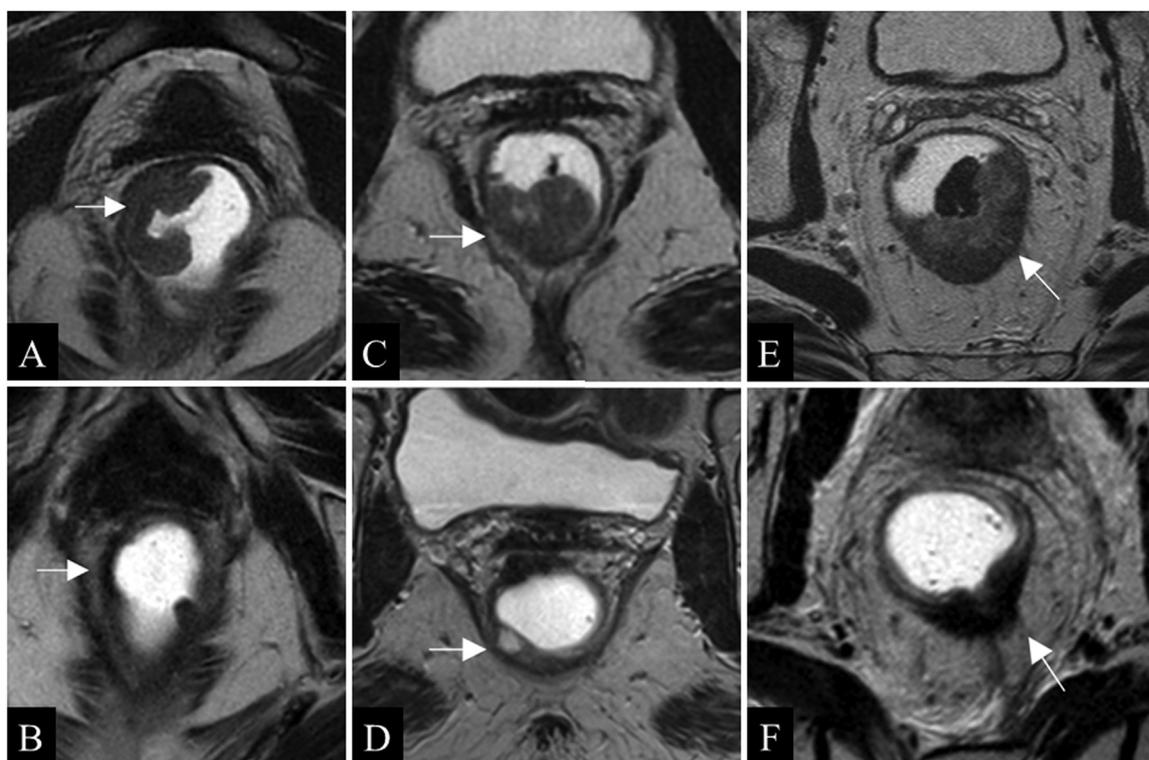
In line with Table 3 lexicon. A, C, E are baseline axial oblique T2-weighted images. B, D, F are post neoadjuvant evaluation MR images. After external chemoradiotherapy, a dense fibrotic scar is shown as hypointense on T2-weighted image in B. D, shows mucinous changes with hyperintense foci on T2-weighted image, F, shows thin spicules within the mesorectal fat indicating desmoplastic reaction.
